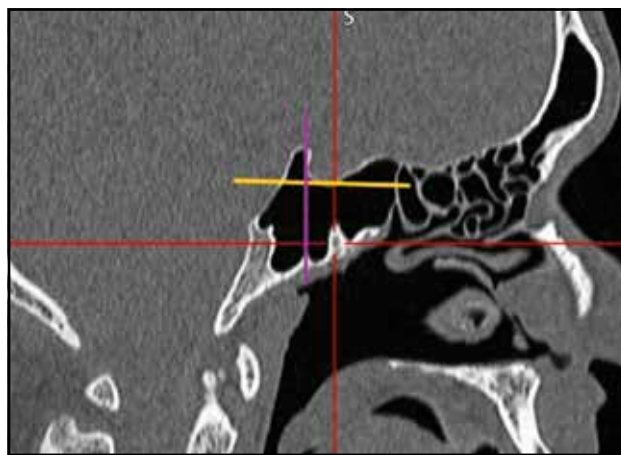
Combined extension (cranio-facial CT scan, sagittal slice; yellow horizontal line- inferior margin of the sella, purple vertical line – the posterior wall of the sella).
